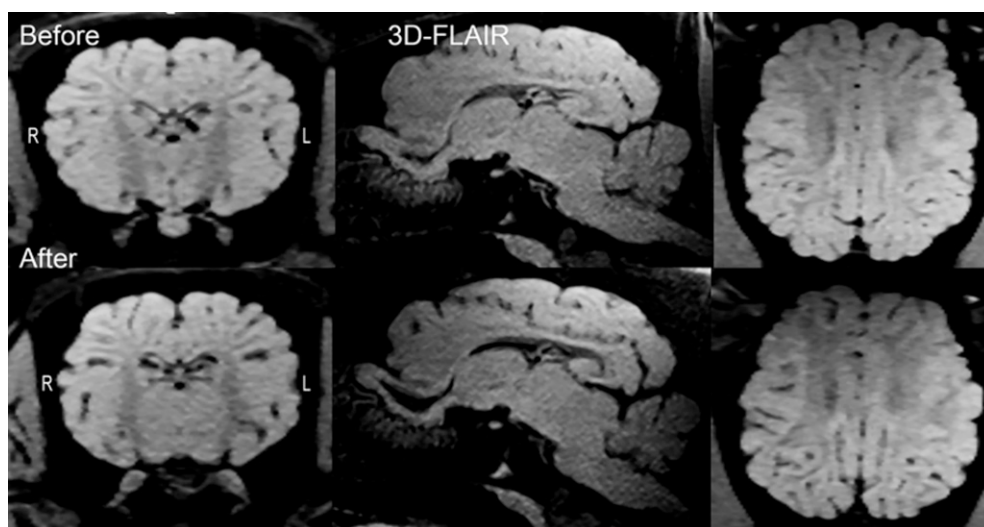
Pre- and postexposure 3-D FLAIR image. Coronal, sagittal, and axial representative images demonstrate clear separation of white and gray matter. No WM hyperintense lesions were apparent in the subcortical and periventricular regions.
